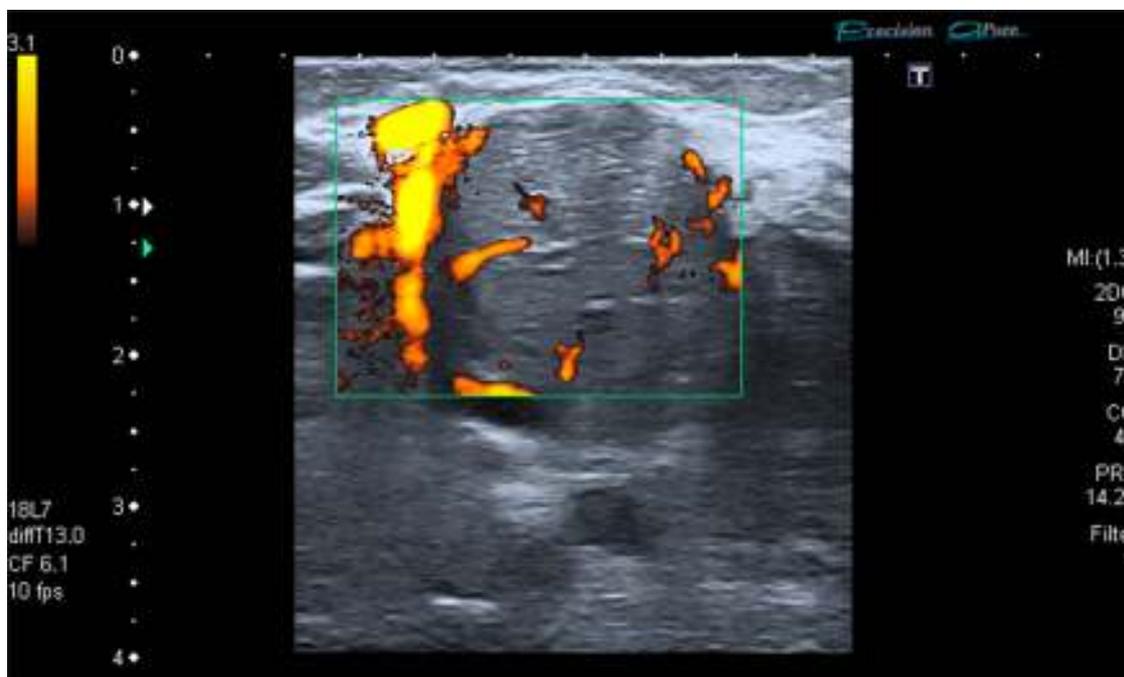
Doppler image showing a round form and grade 1 signal in the lesion and hypervascularity due to an adjacent vessel.
